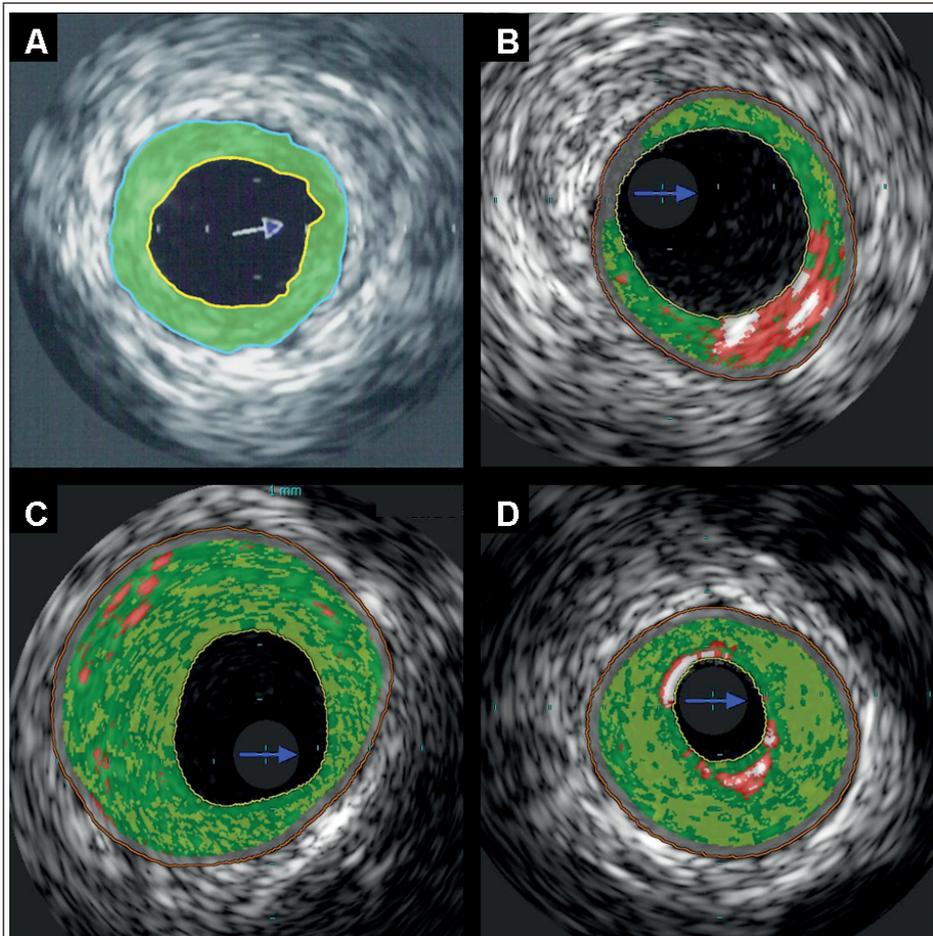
Measurement of plaque burden and identification of high risk lesions with intravascular ultrasound
